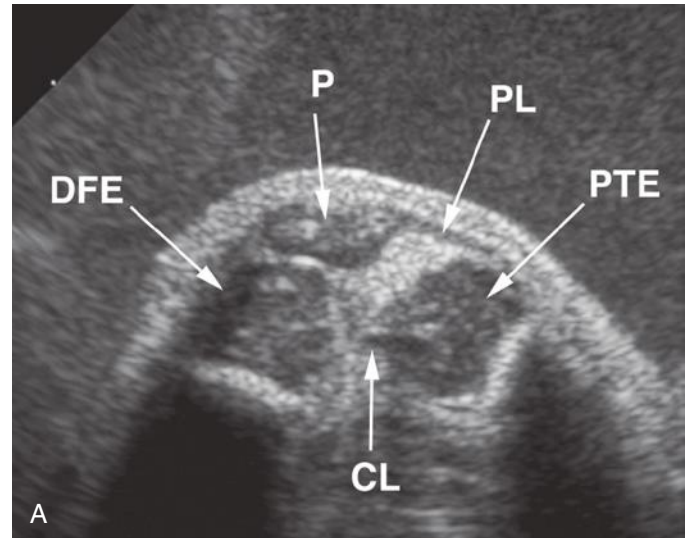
A, Midsagittal sonogram of the fetal knee. B, Axial sonogram (similar to the knee radiograph called the *sunrise view*). Note the echogenic synovium located between the patella, patellar ligament, and epiphyses. P, patella (a bone that is entirely cartilaginous); DFE, distal femoral epiphysis; CL, posterior cruciate ligament; PL, patellar ligament; PTE, proximal tibial epiphysis.
